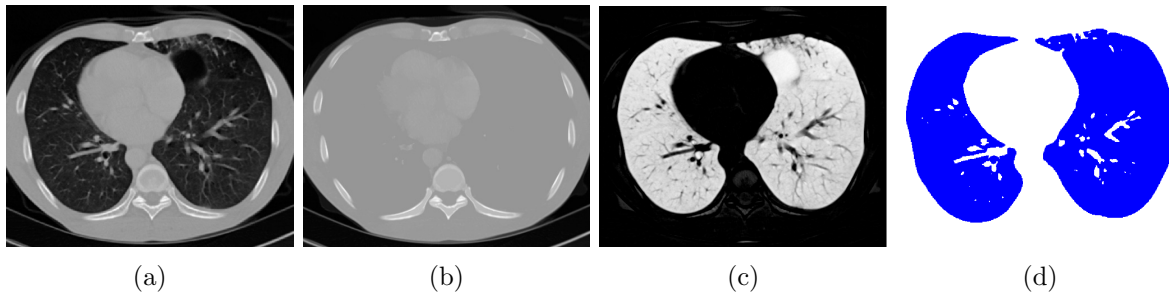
CT pre-processing and posterior clustering for segmenting the respiratory system inside the body. (a): Original CT. (b): Dense-body after filling holes. (c): Absolute difference between (a) and (b). (d): Mask achieved by 2-Means clustering over (c).
